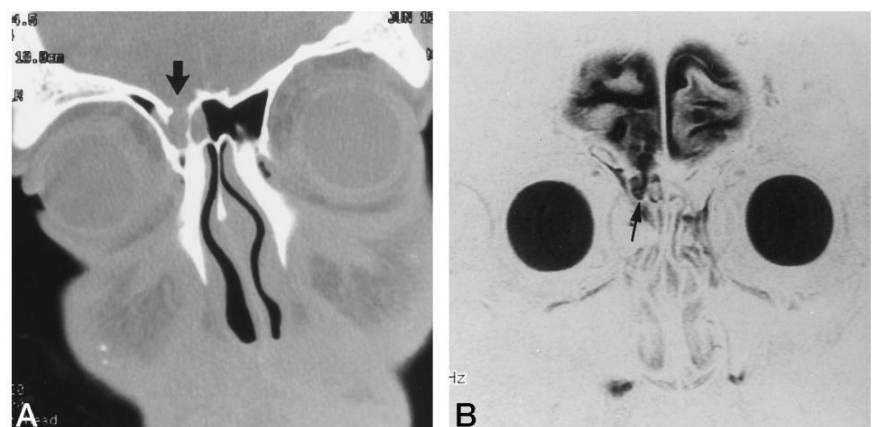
A: Corresponding reformatted coronal CT scan in patient from Fig. 45.3 demonstrates an extensive cribriform plate/ethmoid roof defect with resultant meningoencephalocele. B: Coronal T2-weighted MR shows that the mass contains both CSF and brain parenchyma.
